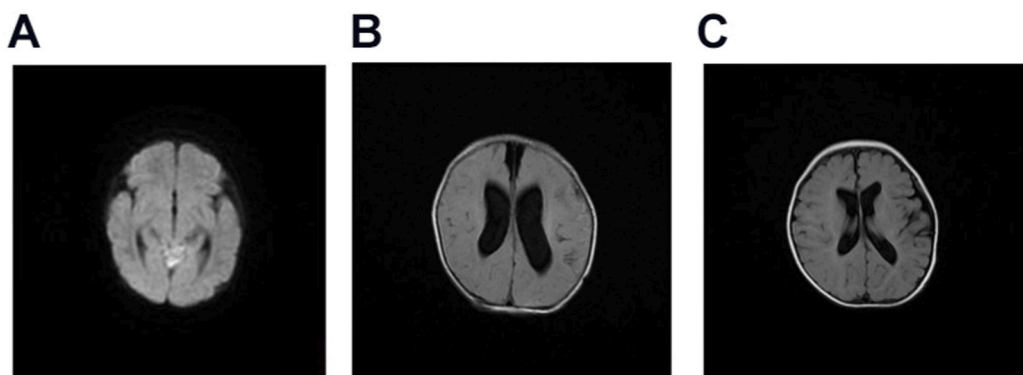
The results of cranial plain MRI + DWI.
